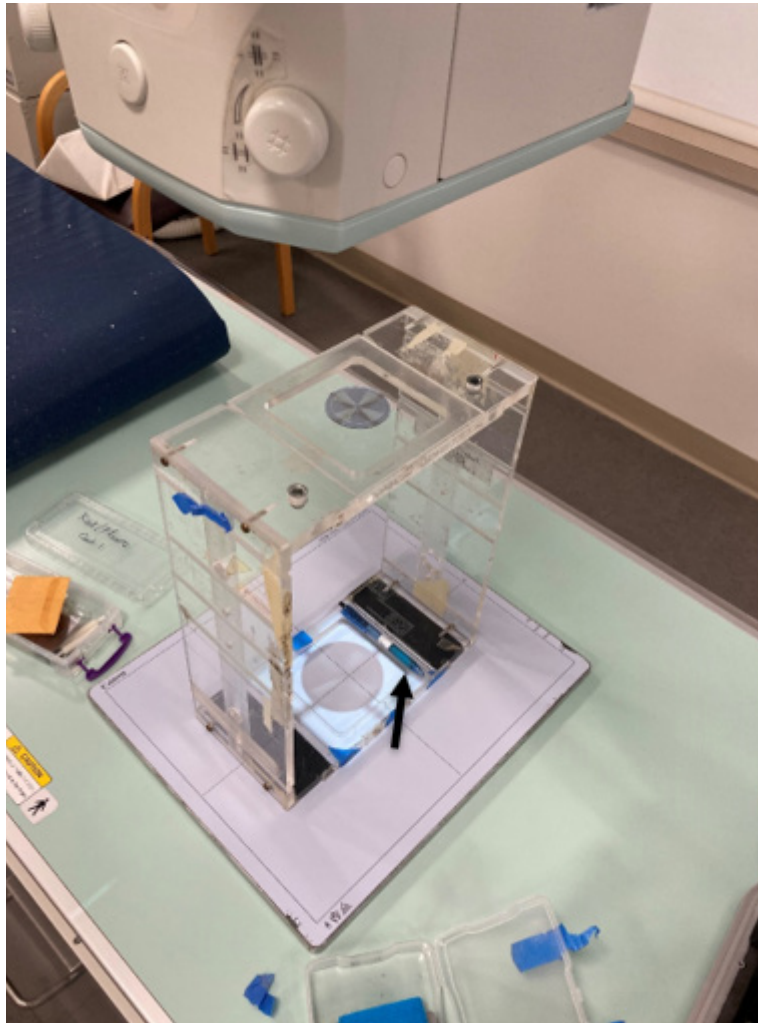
Setup for measuring focal spot size using star pattern. Note the pen (indicated by arrow) used to mark the anode-cathode axis. By measuring with the image receptor on the patient table, it is possible to determine the radiographic magnification precisely.
